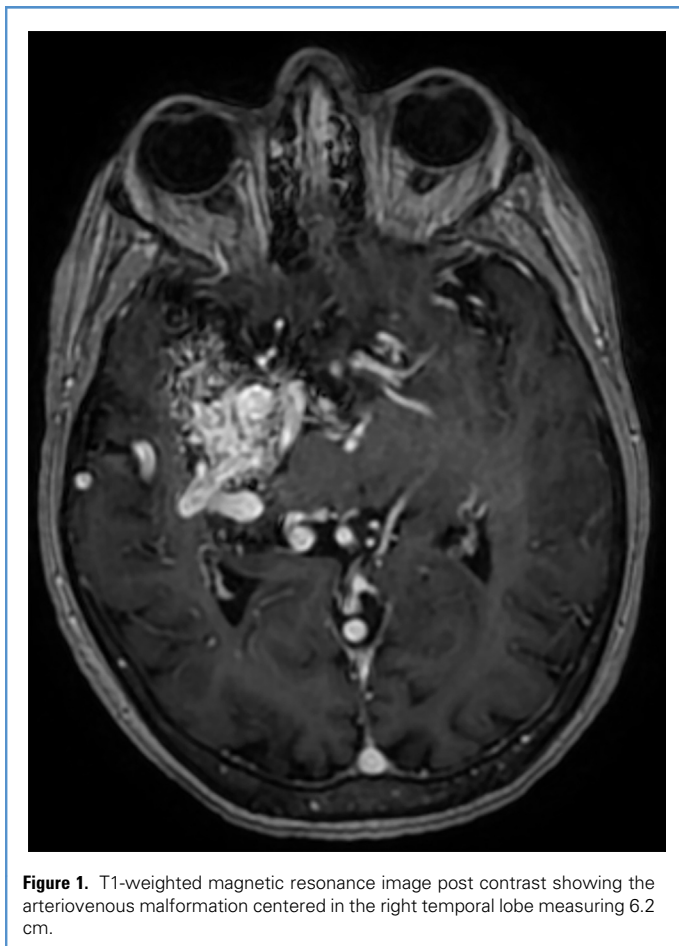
T1-weighted magnetic resonance image post contrast showing the arteriovenous malformation centered in the right temporal lobe measuring 6.2 cm.
